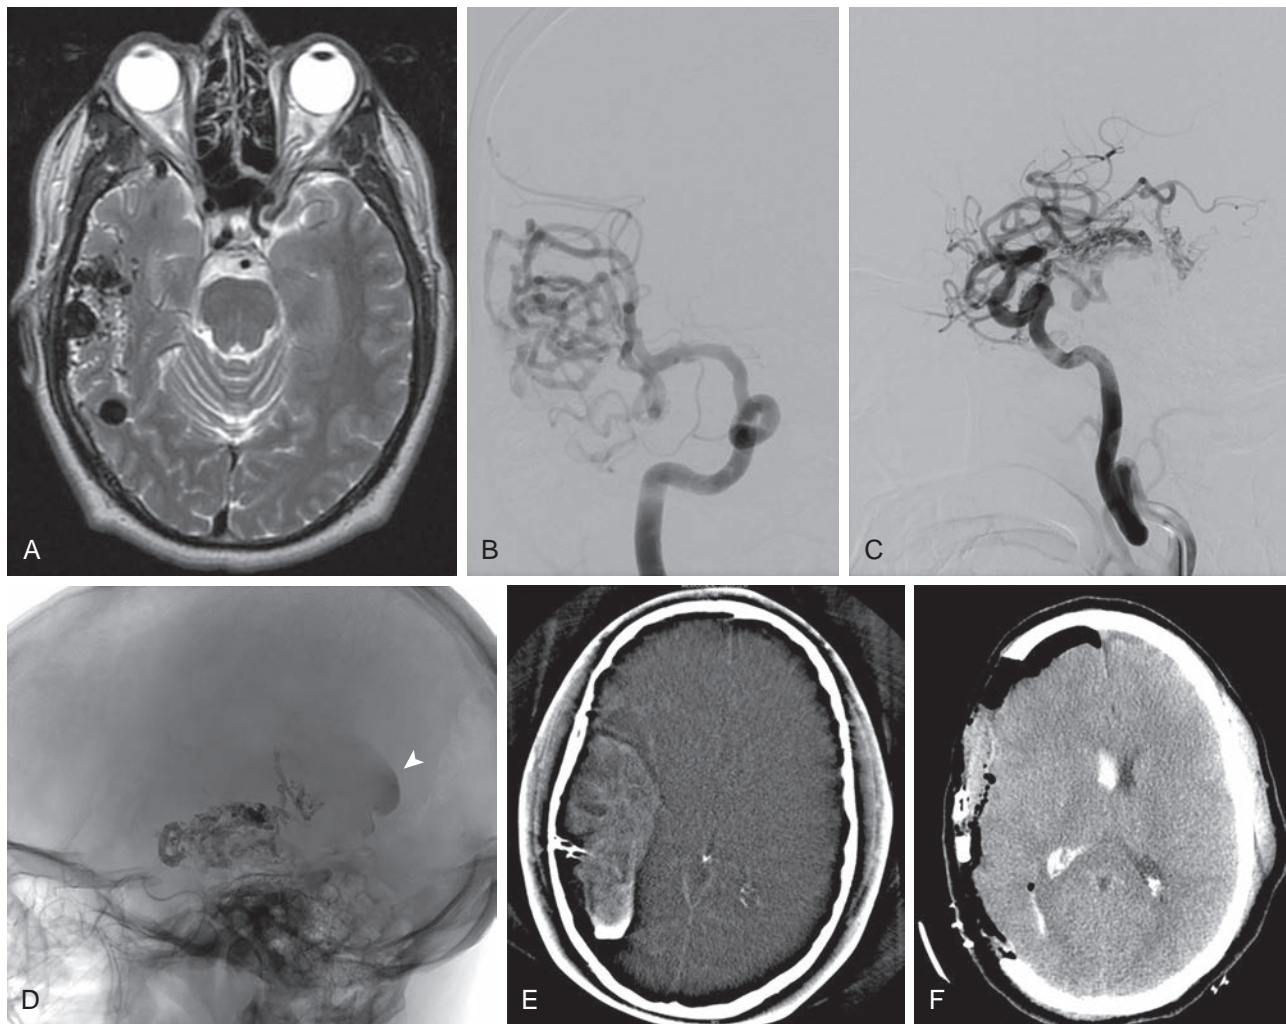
Hemorrhage after AVM embolization. Axial T2 MRI shows prominent flow voids within the right temporal lobe consistent with the presence of an AVM (A). Internal carotid arteriogram in anteroposterior (B) and lateral (C) projections shows the intricate arterial network of the AVM nidus fed by branches of the middle cerebral artery. Intracanal NBCA glue is clearly visualized on postembolization lateral skull x-ray (D). Extravasated blood is also seen posterior to the glue cast in the temporal-occipital region (arrowhead). DynaCT rotational fluoroscopy indicates the presence of a large hemorrhage, which may be due to NPPB phenomena immediately after embolization (E). Postoperative noncontrast head CT shows excellent decompression after hemicraniectomy, ICH evacuation, and AVM resection (F).
